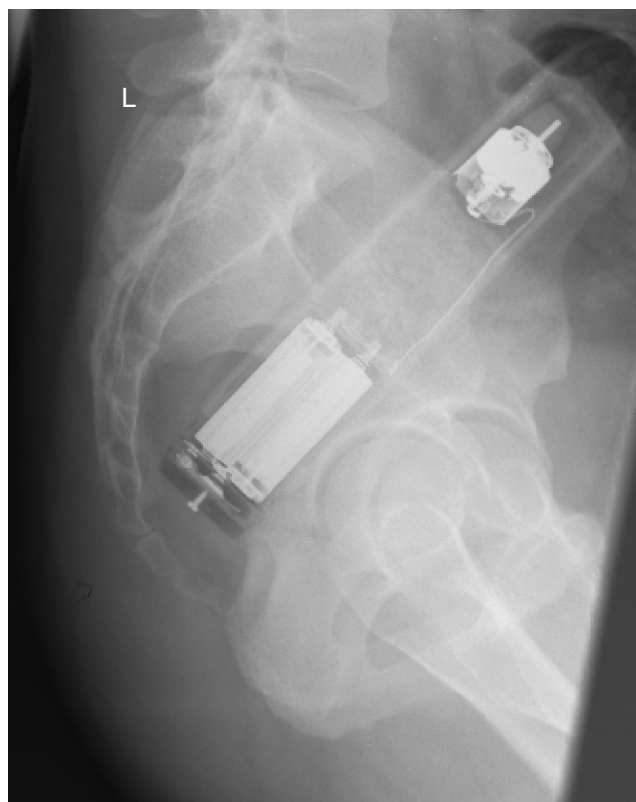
Plain x-ray showing vibrator in the rectum in an adult patient
